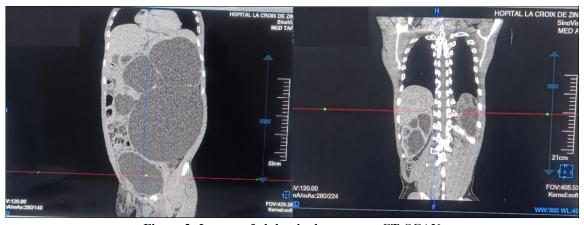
Images of abdominal masses on CT-SCAN
